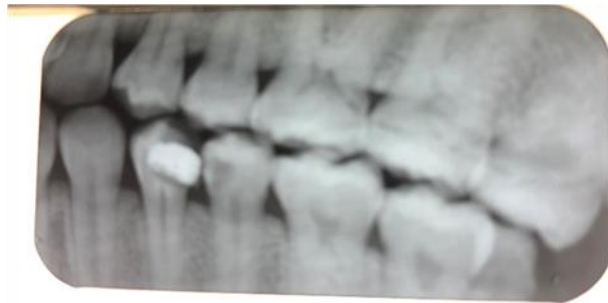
Conventional bitewing image with radiolucency in inner half of dentin (R4).
